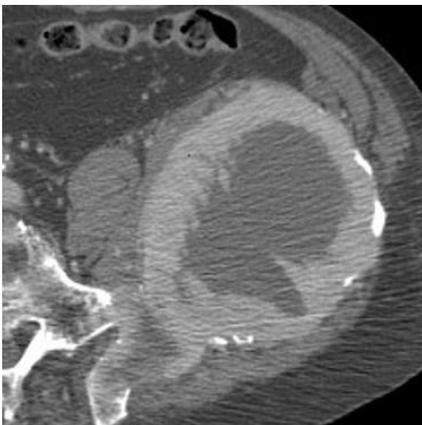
A 68-year-old man with severe pain in left iliac fossa due to iliac metastasis from thyroid cancer. CT image shows a wide osteolytic lesion with important hypervascular peripheral component.
